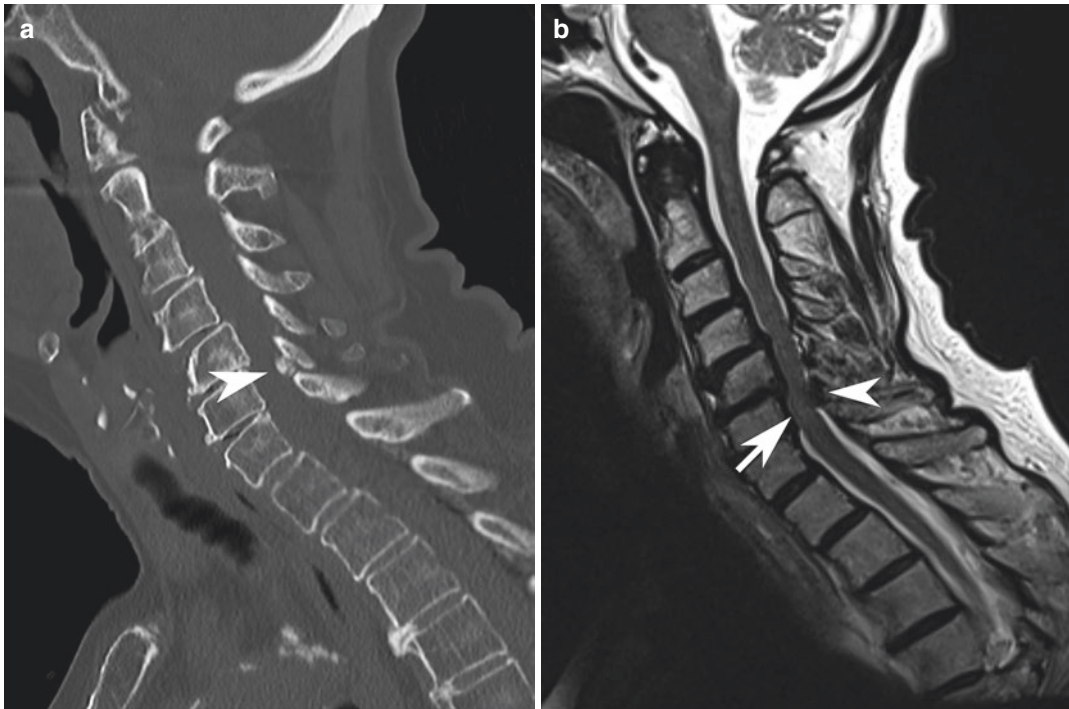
Reformatted sagittal CT (a) and T2-weighted (b) images showing spinal age-related changes of an elderly lady resulting in stenosis of the cervical canal at C5–6 due
